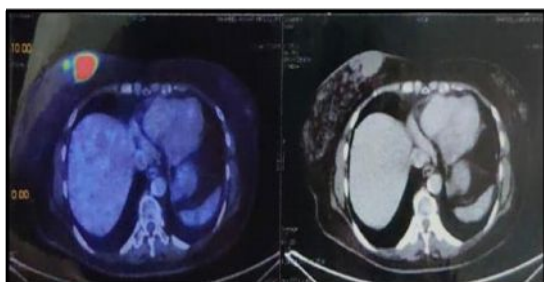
PET CT Showing Irregular lobulated Solid Lesion in Upper and Lower Inner Quadrant of Right Breast
